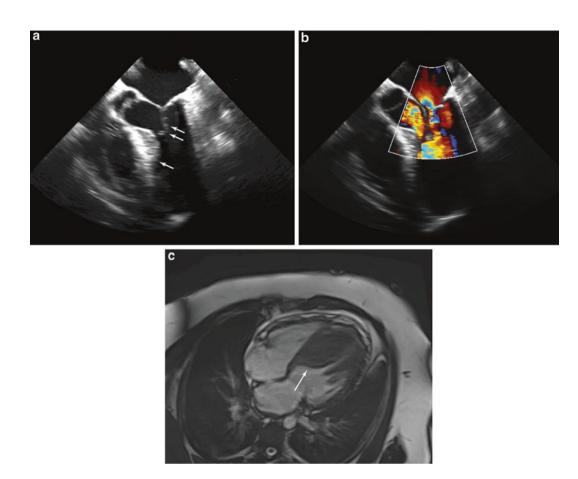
(a) Hypertrophic cardiomyopathy. Transesophageal echocardiogram. Four-chamber view. Markedly thickened interventricular septum (IVS) (arrow). The anterior leaflet of mitral valve displaced toward the IVS (SAM) narrows the LV outflow tract (arrows). (b) Color Doppler shows posteriorly directed jet of mitral regurgitation. (c) Cardiac MRI. Axial view. Marked thickness of IVS (*arrow*). In contrast, thickness of posterior wall (PWLV) is normal
